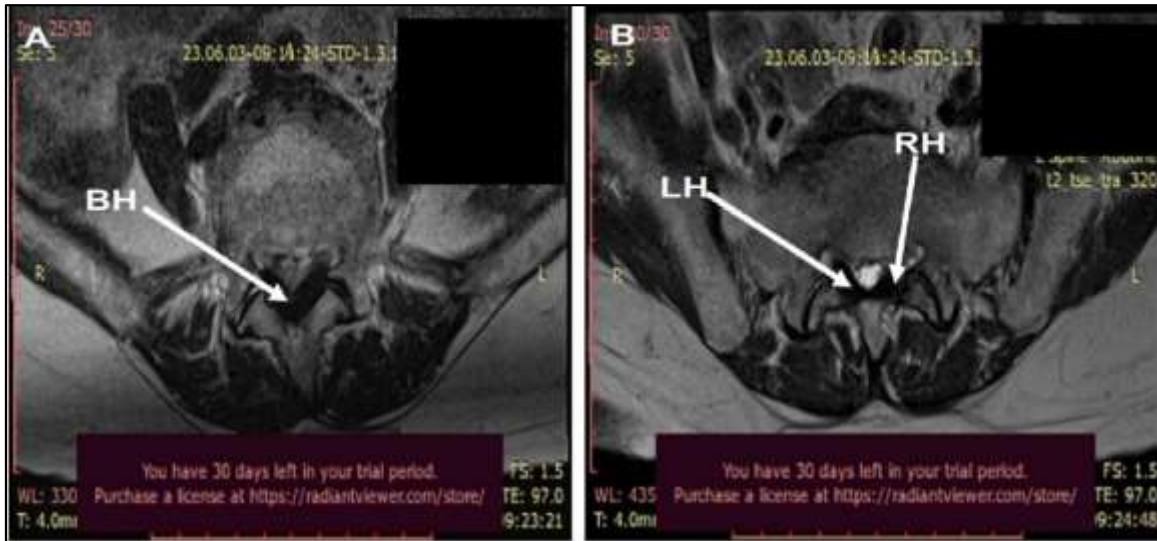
MRI axial view of the lumbar spine showing ligamentum flavum hypertrophy causing compression of bilateral nerve roots.
